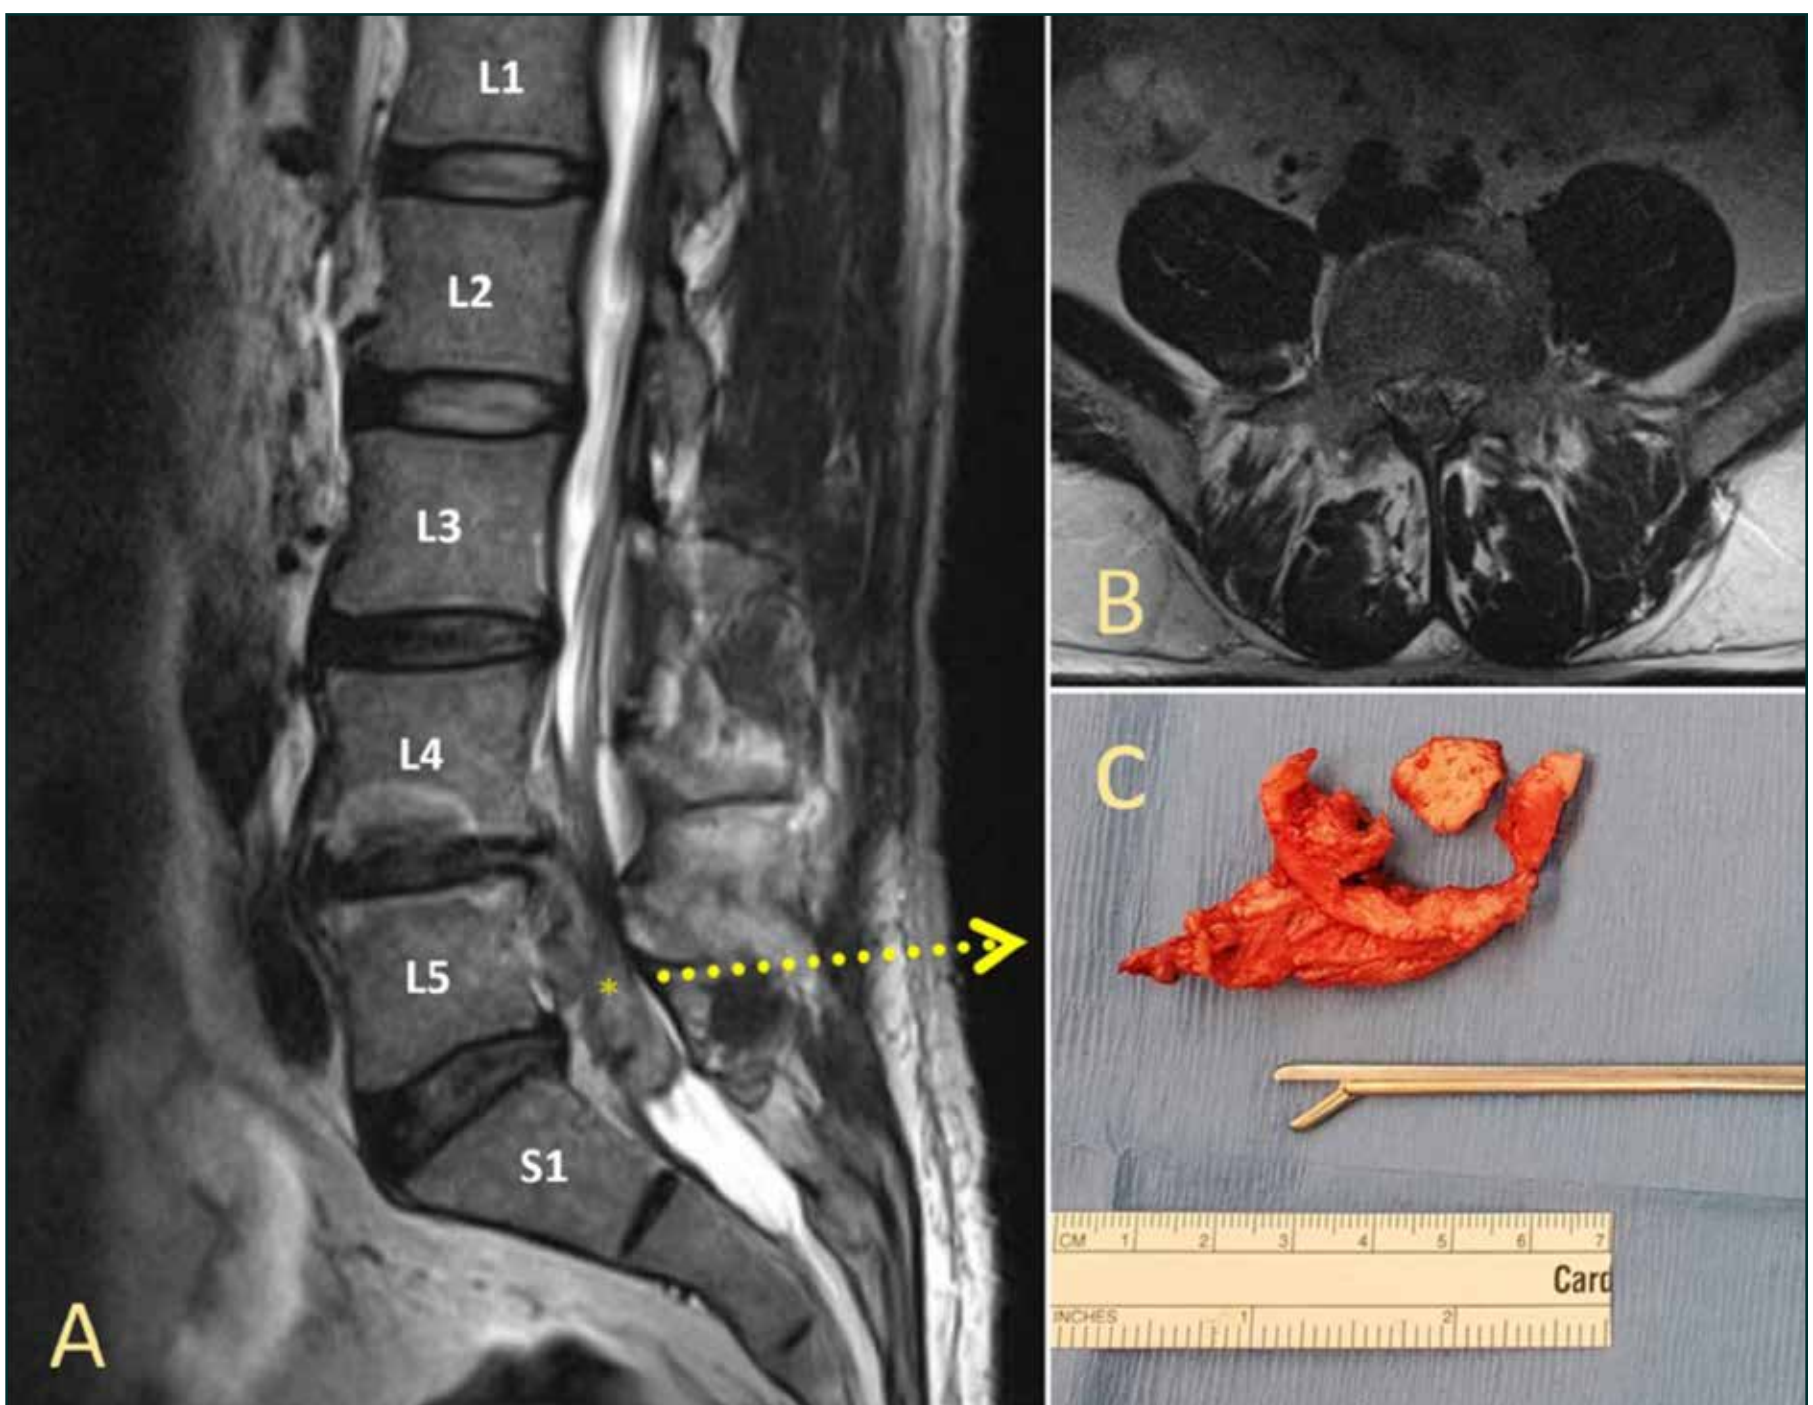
T2 mid-sagittal (A) magnetic resonance imaging of the lumbar spine showing a large herniated L4/5 disc with the corresponding axial (B) cut showing severe canal stenosis. Following herniated disc removal after surgery (C).
